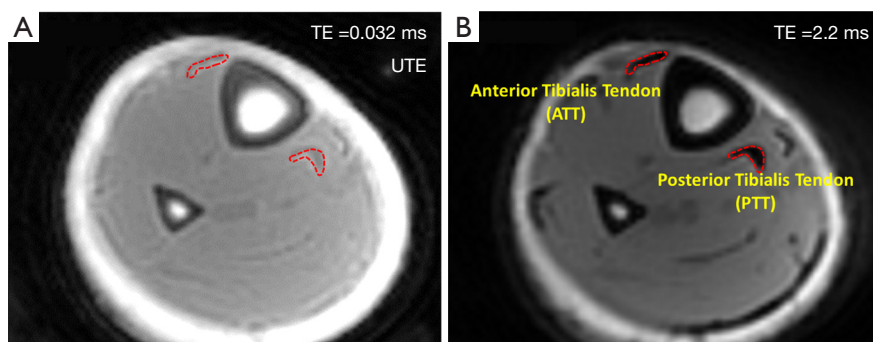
Representative axial images of the ATT and PTT of a healthy 25-year-old female subject. (A) Axial image acquired with UTE Cones MRI sequence (TE =0.032 ms). (B) Axial image acquired with Cones MRI sequence at TE =2.2 ms. Representative ROIs for the anterior and posterior tibialis tendons (ATT and PTT) were selected at TE =2.2 ms as it provided higher contrast (indicated by the red dashed boundary). TE, echo time; UTE, ultrashort echo time; ATT, anterior tibialis tendon; PTT, posterior tibialis tendon; MRI, magnetic resonance imaging; ROI, region of interest.
